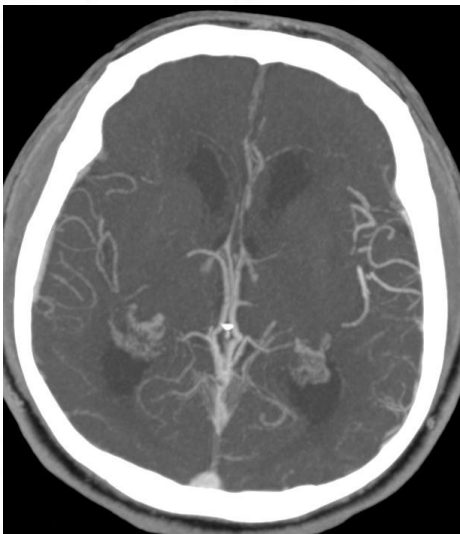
Axial CT MIP single phase showing good collateral score (TAN grade 2)
